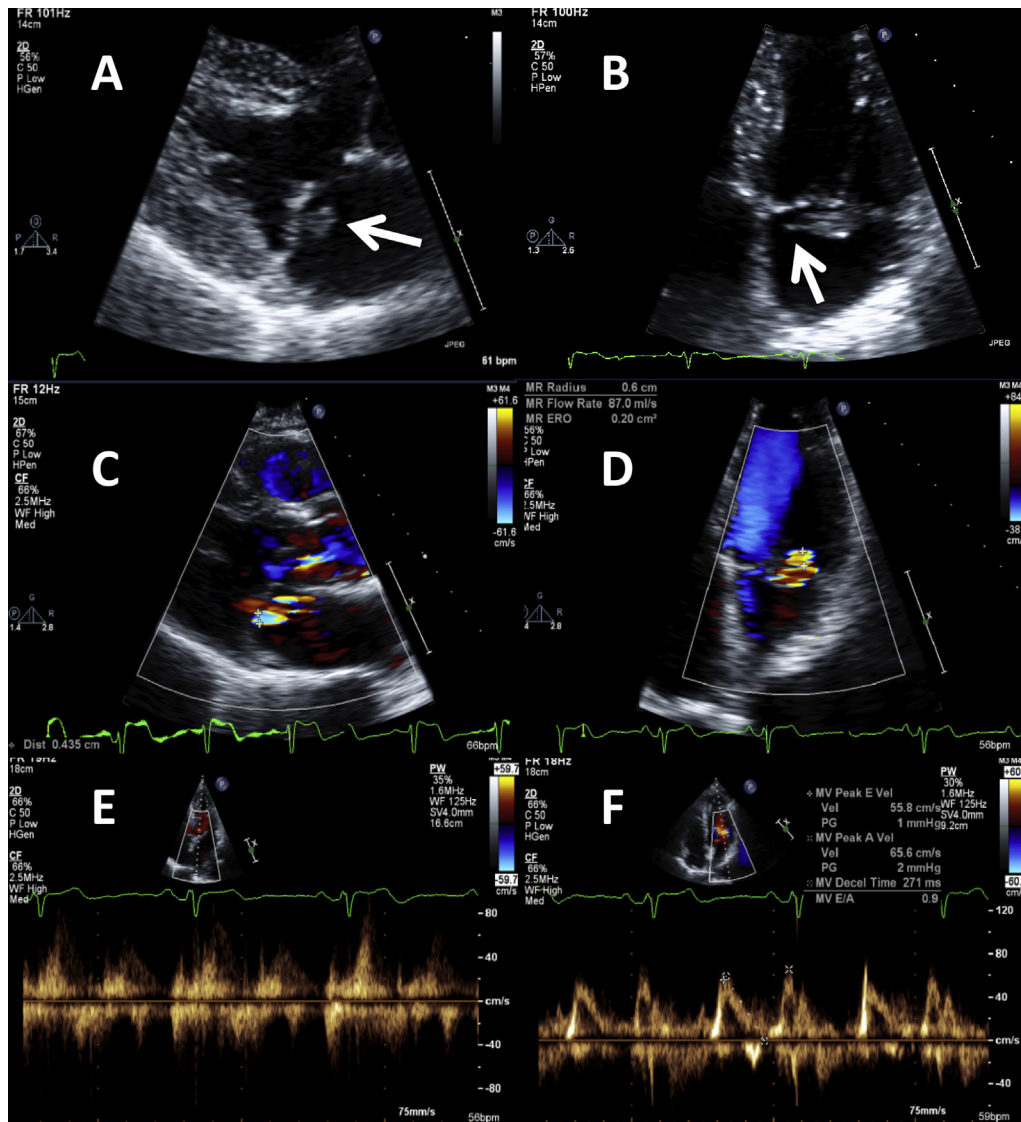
Representative case (case 9, Tables 1–3) of a flail mitral leaflet with moderate MR. Parasternal long-axis view (A) and apical four-chamber view (B) on TTE display a flail posterior mitral leaflet (white arrows). (C) Color Doppler imaging from a parasternal long-axis view on TTE shows an eccentric MR jet with a vena contracta diameter of 4.4 mm, consistent with moderate MR. (D) Color Doppler imaging from an apical four-chamber view on TTE shows a PISA radius of 6 mm, consistent with moderate MR. (E) Pulsed-wave Doppler signal of the pulmonary vein inflow obtained from the apical four-chamber view on TTE reveals systolic predominant flow, consistent with normal left atrial filling pressure. (F) Pulsed-wave Doppler signal from the mitral inflow obtained from the apical four-chamber view on TTE reveals normal E velocity and A-wave predominance, consistent with normal left atrial filling pressure.
